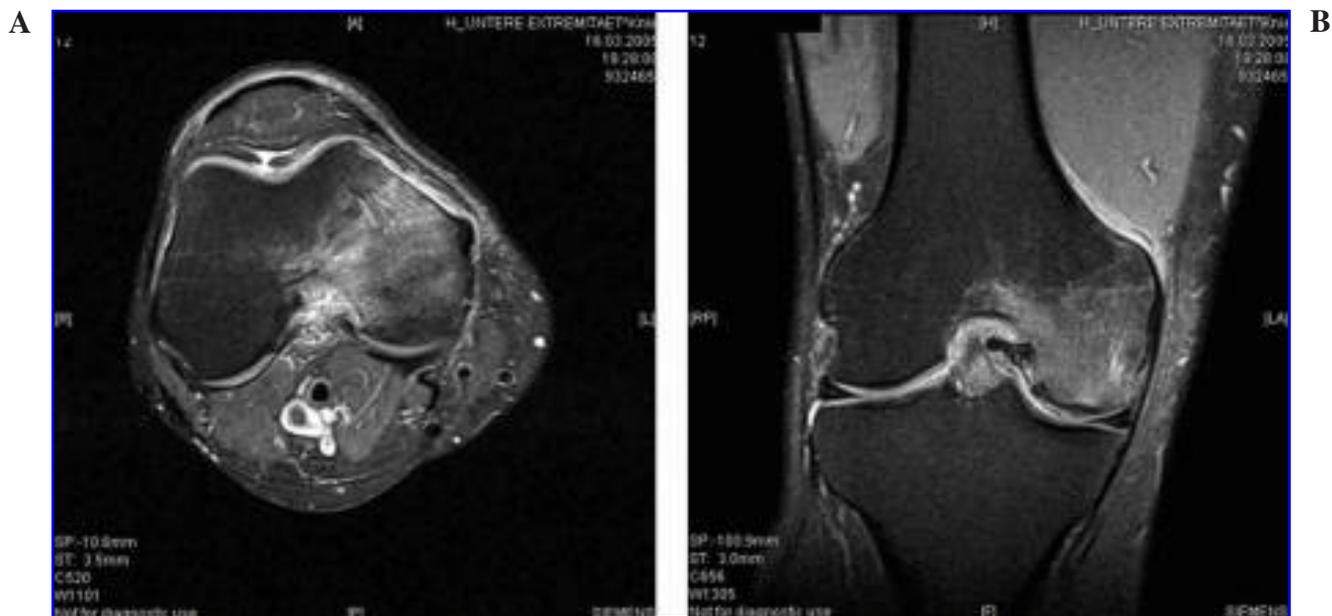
These MRI images, made March 16, 2005, are a coronary fat-suppressed PD TSE sequence. (A) Axial and (B) frontal images, showing a linearly subcortical focus at the medial femur condyle with adjacent spongiosa edema (necrotic zone) reaching deep into the bone marrow.
